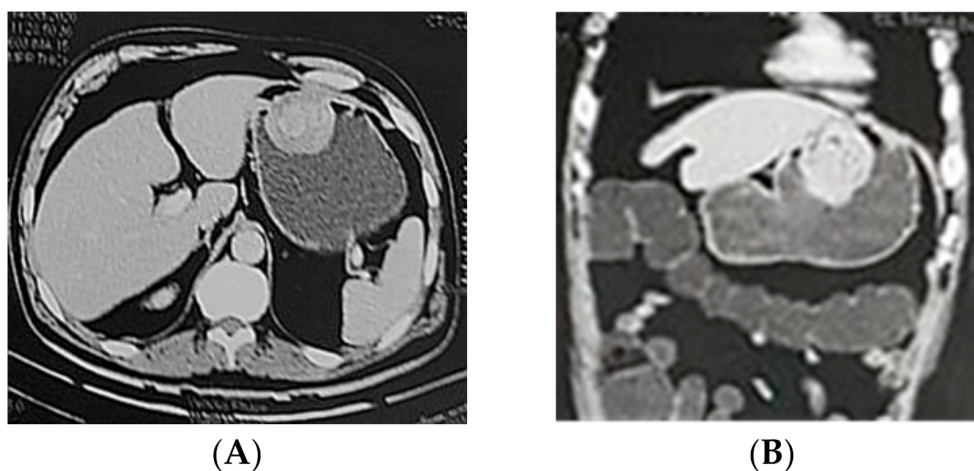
Axial (A) and coronal (B) CT enterocolonography showing anterior gastric wall endophytic mass lesion. No outlet obstruction or serosal involvement identified.
